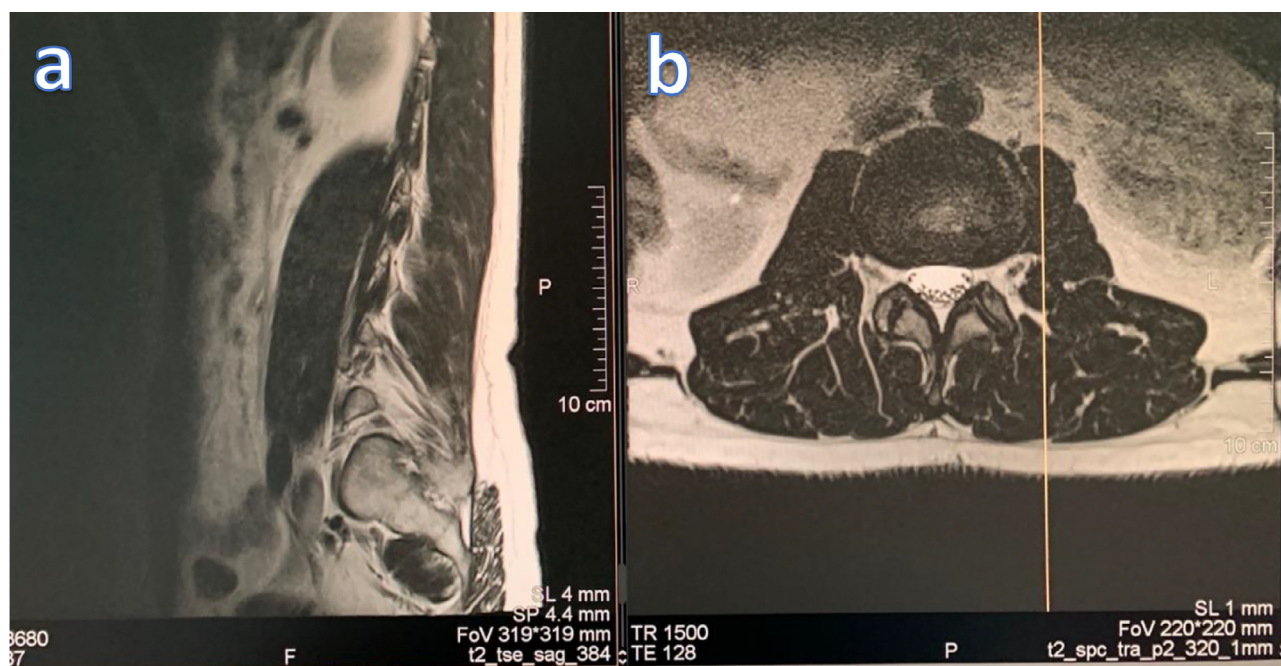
(a) sagittal and (b) axial T2-weighted space sequence shows lateral disc hernia at the L2-L3 level progressing towards the left psoas muscle (shown by arrow)
